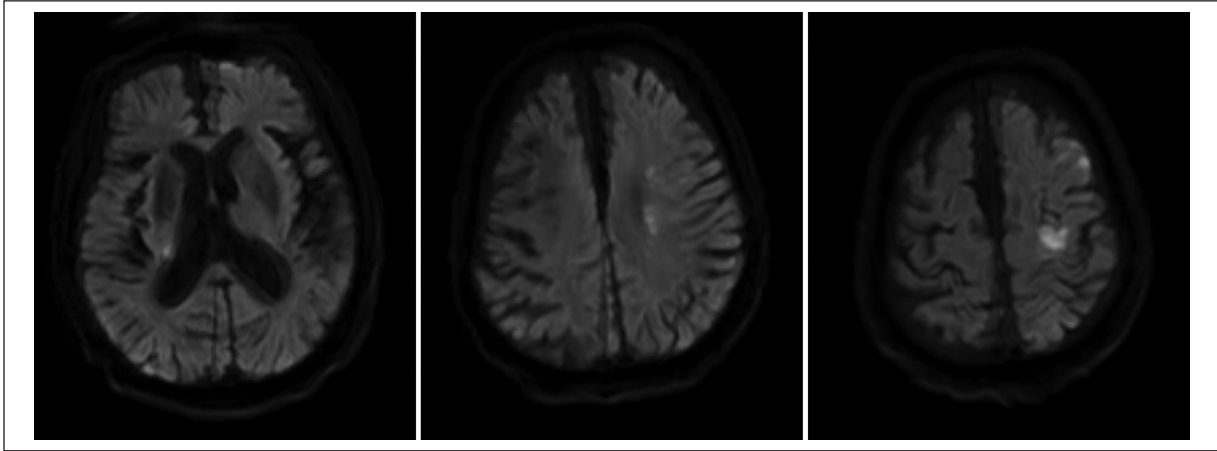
Brain magnetic resonance imaging with diffusion-weighted imaging reveals multiple acute brain infarcts.
